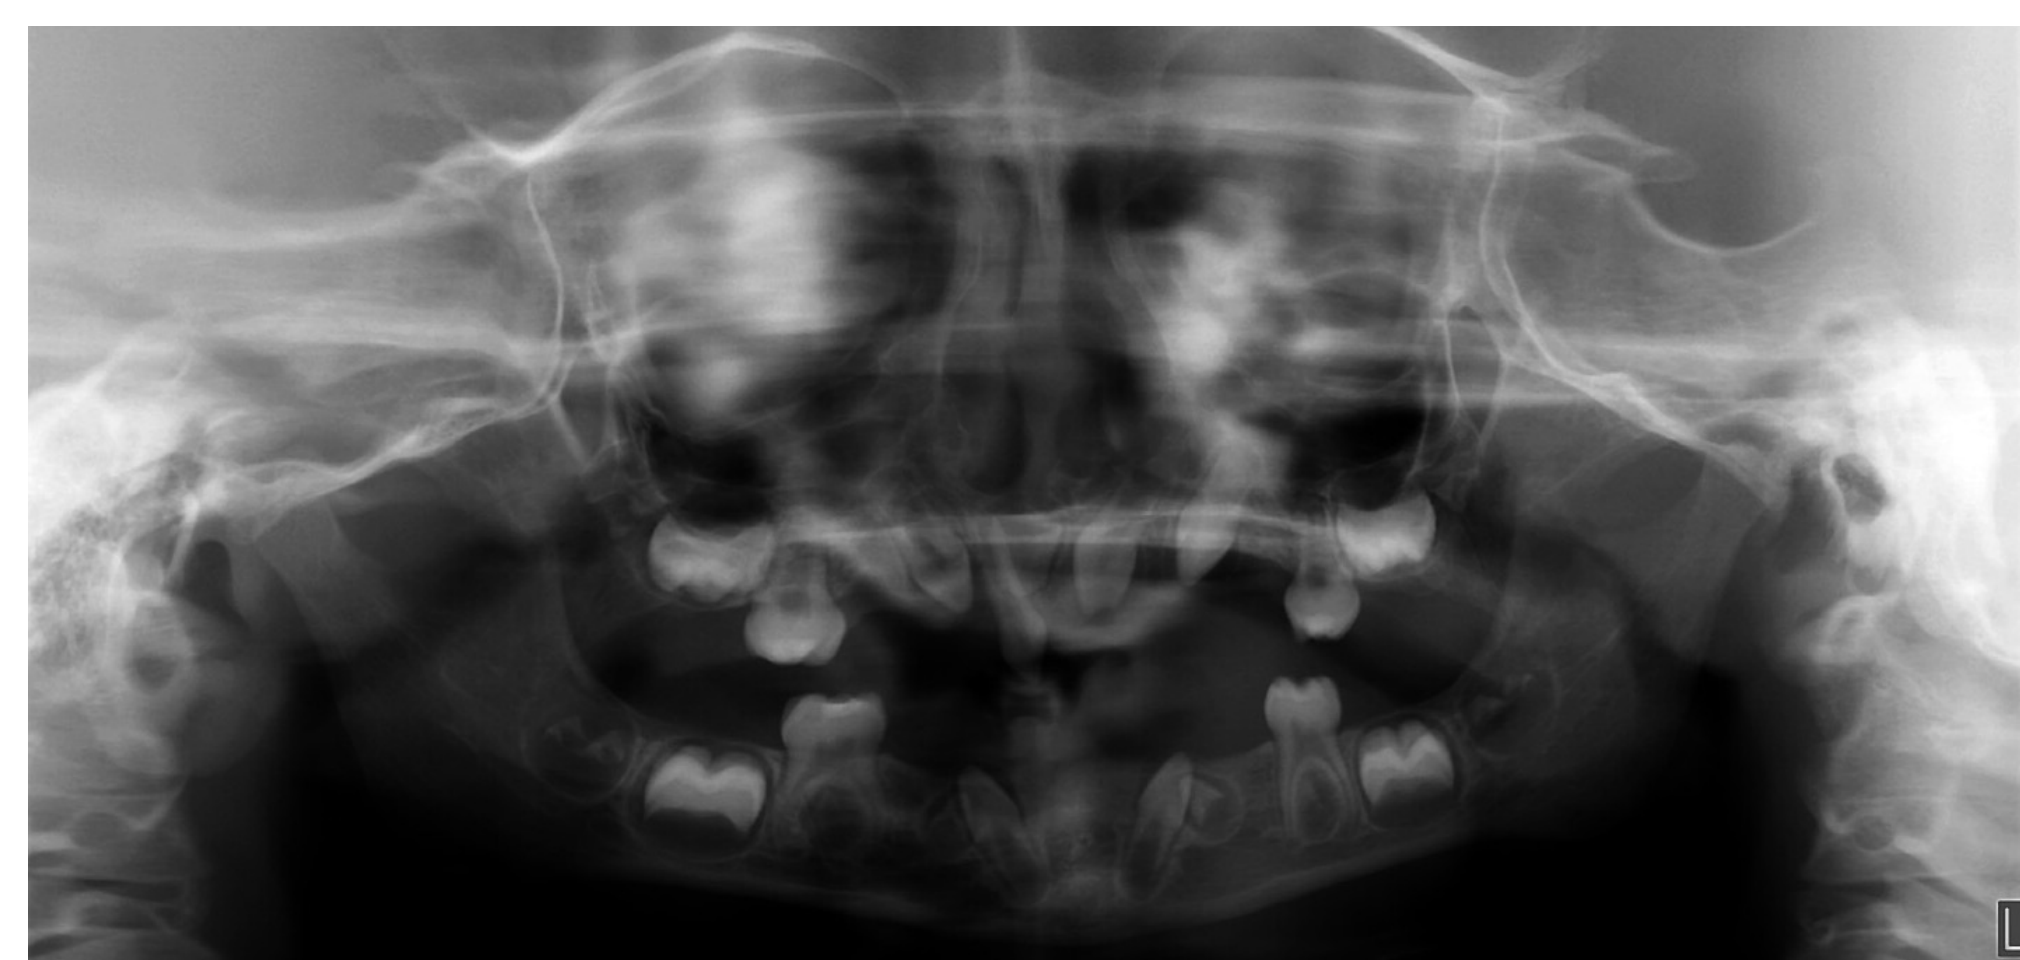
Panoramic radiograph at age of 3-year-old
